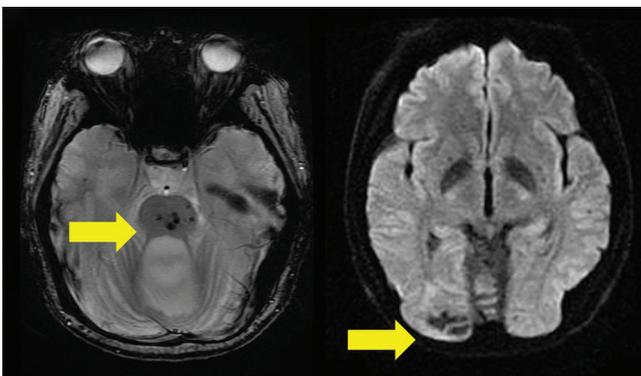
Magnetic resonance imaging of brain showed old hemorrhages in pons and right occipital lobe
